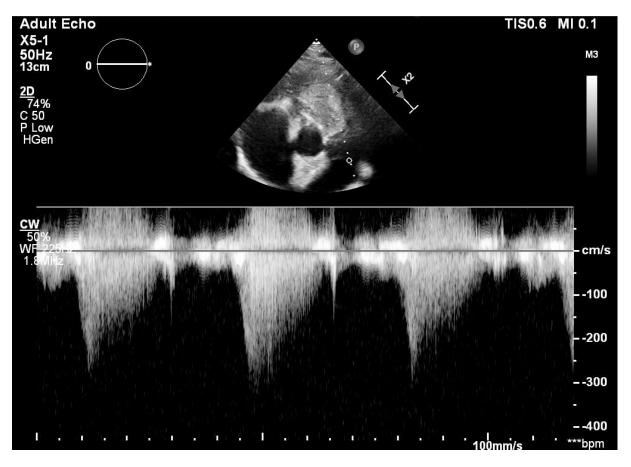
CW-Doppler revealing approximately 36 mmHg systolic gradient in right ventricular outflow tract and pulmonary artery. Parasternal short axis view.
